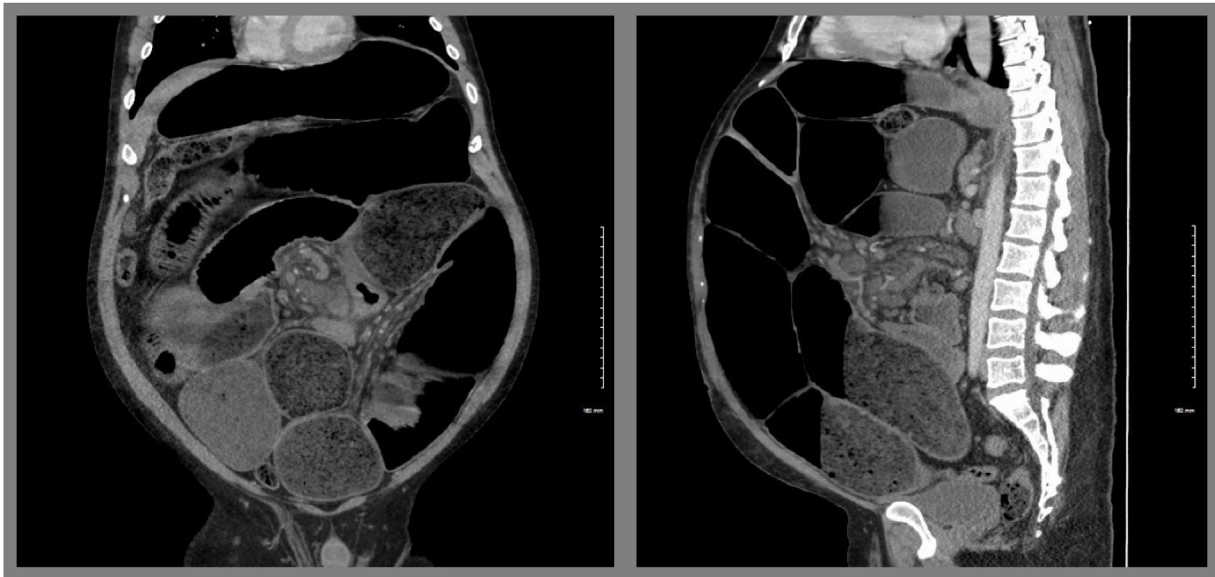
A. Coronal and B. Saggital views from the initial CT in the ED, showing massively distended small bowel loops with multiple air-fluid levels.
